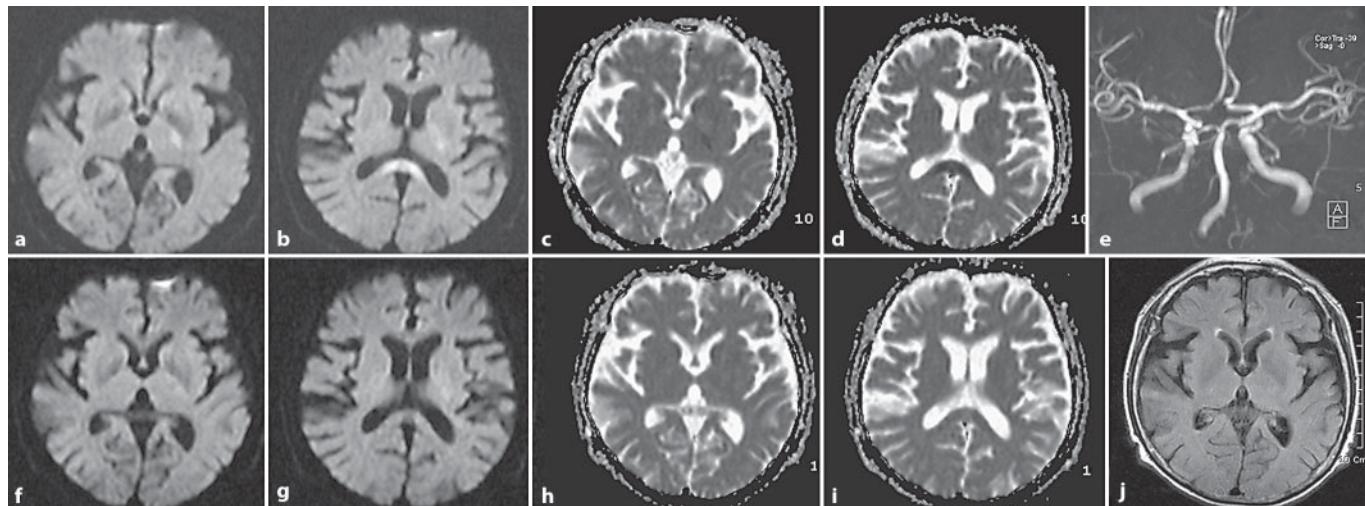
Initial diffusion-weighted imaging (DWI) at the time of profound hypoglycemia showed hypersignals in the posterior limb of left internal capsule and splenium of corpus callosum with reduced apparent diffusion coefficient (ADC) values (a–d). A simultaneous MR angiography showed no evidence of significant stenosis or spasm in the major intracranial arteries (e). Repeat DWI performed 12 h after correction of profound showed complete resolution of the lesions with normalized ADC values (f–i). Another fluid-attenuated inversion recovery (FLAIR) MRI performed 3 days later showed no residual lesion (j).
